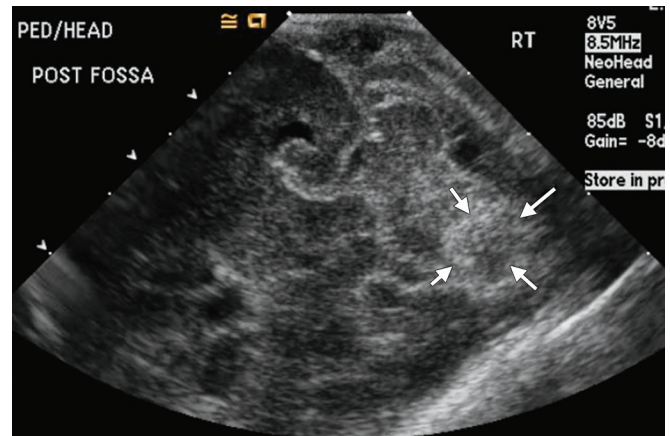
Sonographic image of the cerebellum obtained through the right mastoid fontanelle in a premature infant on day of life 7, showing an ill-defined focal hyperechoic area in the left cerebellar hemisphere (white arrows) consistent with a grade 3 CBH
